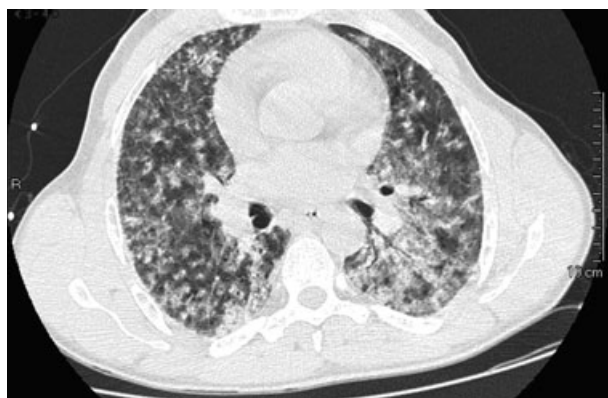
The first CT-scan image performed at the peripheral (referring) hospital.
